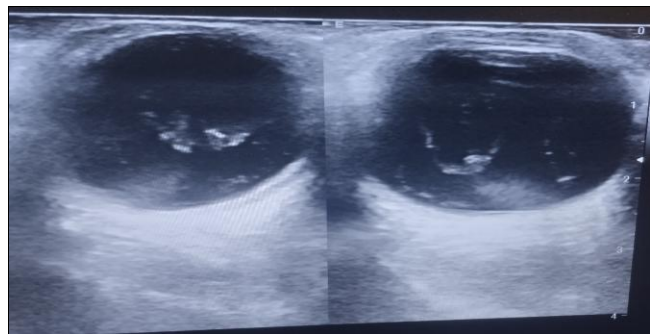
Bilateral B-mode ocular ultrasonography demonstrating multiple heterogeneous moderate- to high-level echogenic opacities within both vitreous cavities, consistent with bilateral vitreous haemorrhages
